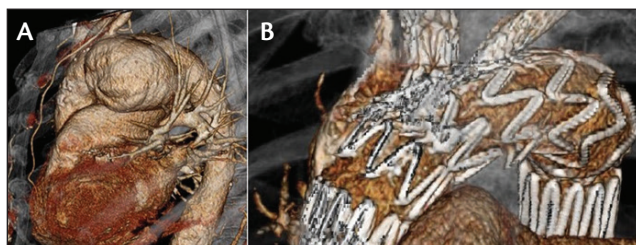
Preoperative (A) and postoperative (B) CTA imaging of a patient with an aortic arch aneurysm who underwent implantation of the Zenith arch device with branches for the innominate artery and LCCA.
